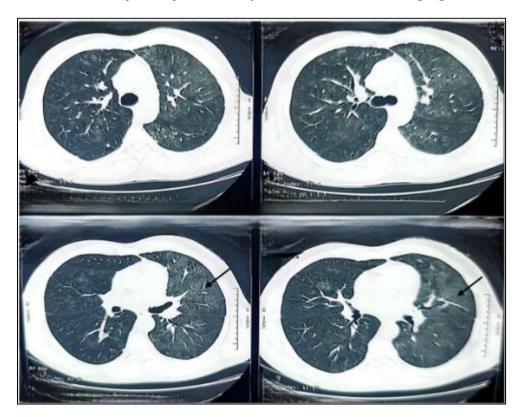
Chest computed tomography in the parenchymal window showing alveolar hemorrhage. Slices show diffuse bilateral ground-glass opacities with sparing of the subpleural region, suggestive of alveolar hemorrhage
